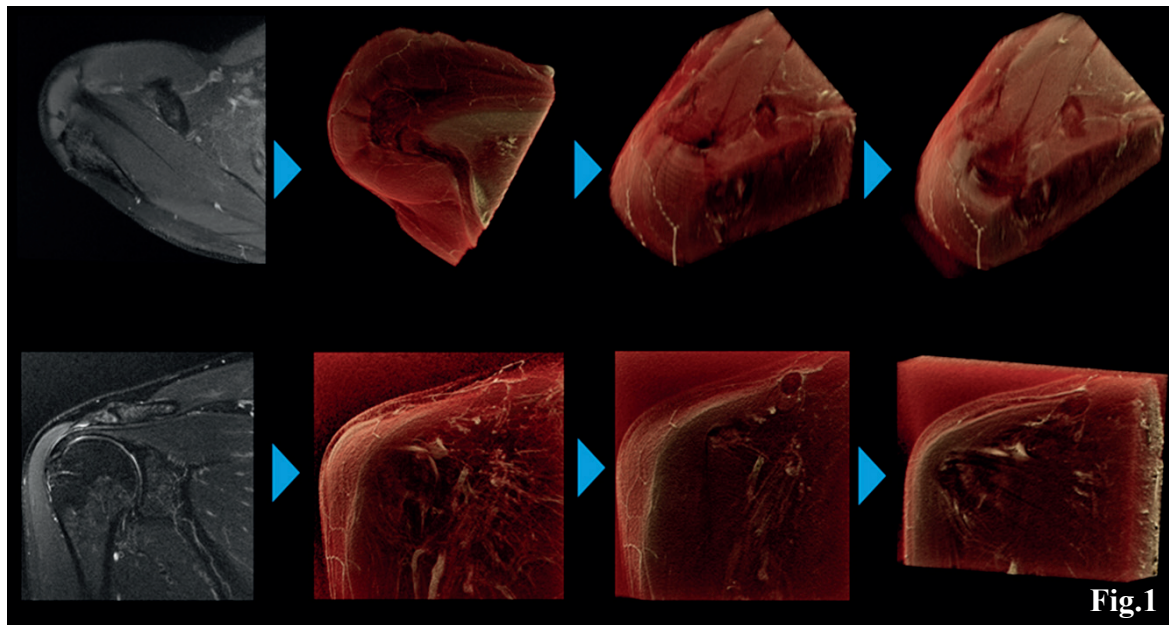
The processing steps of 3D Cinematic VR images of supraspinatus tendon (upper row) and subscapularis tendon (lower row). The axial and coronal fluid-sensitive images of the MRI shoulder were post processed on Syngovia for 3D VR image creation. Further clipping and punching out process were followed to remove the overlying deltoid muscles and acromioclavicular (AC) joint. The resulted volume of VR images revealed clearly anatomical structure for interpretation.
